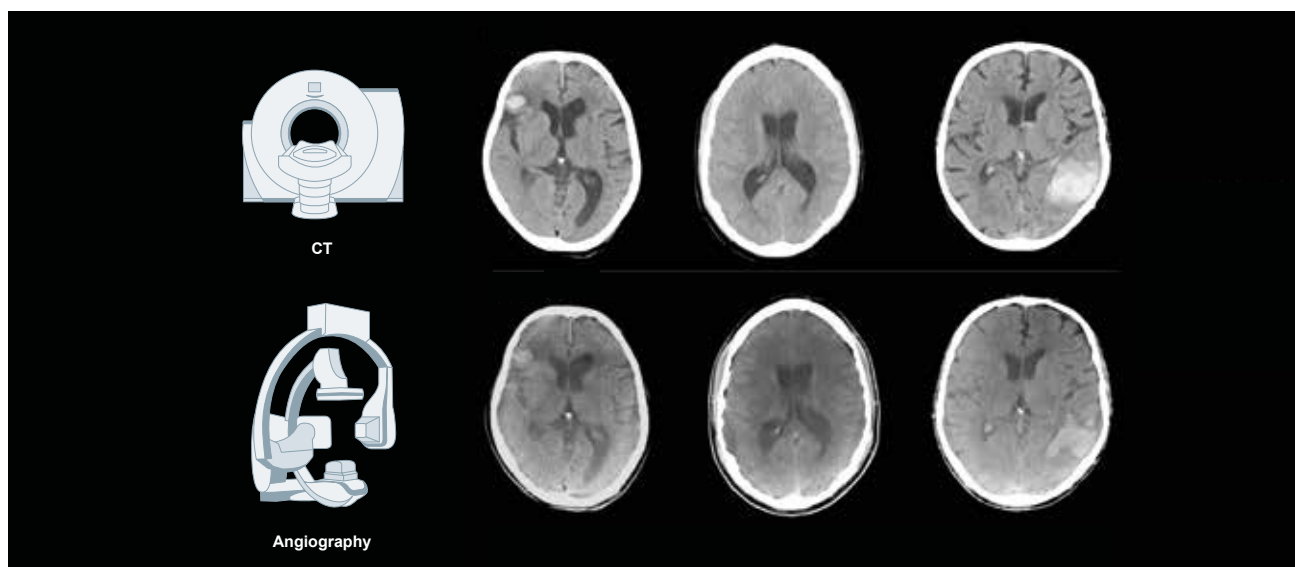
CT vs *syngo* DynaCT to determine whether stroke is haemorrhagic or ischaemic: One step ahead with Artis Q. Images courtesy of Prof. Skalej, Neuroradiology, Magdeburg, Germany.
